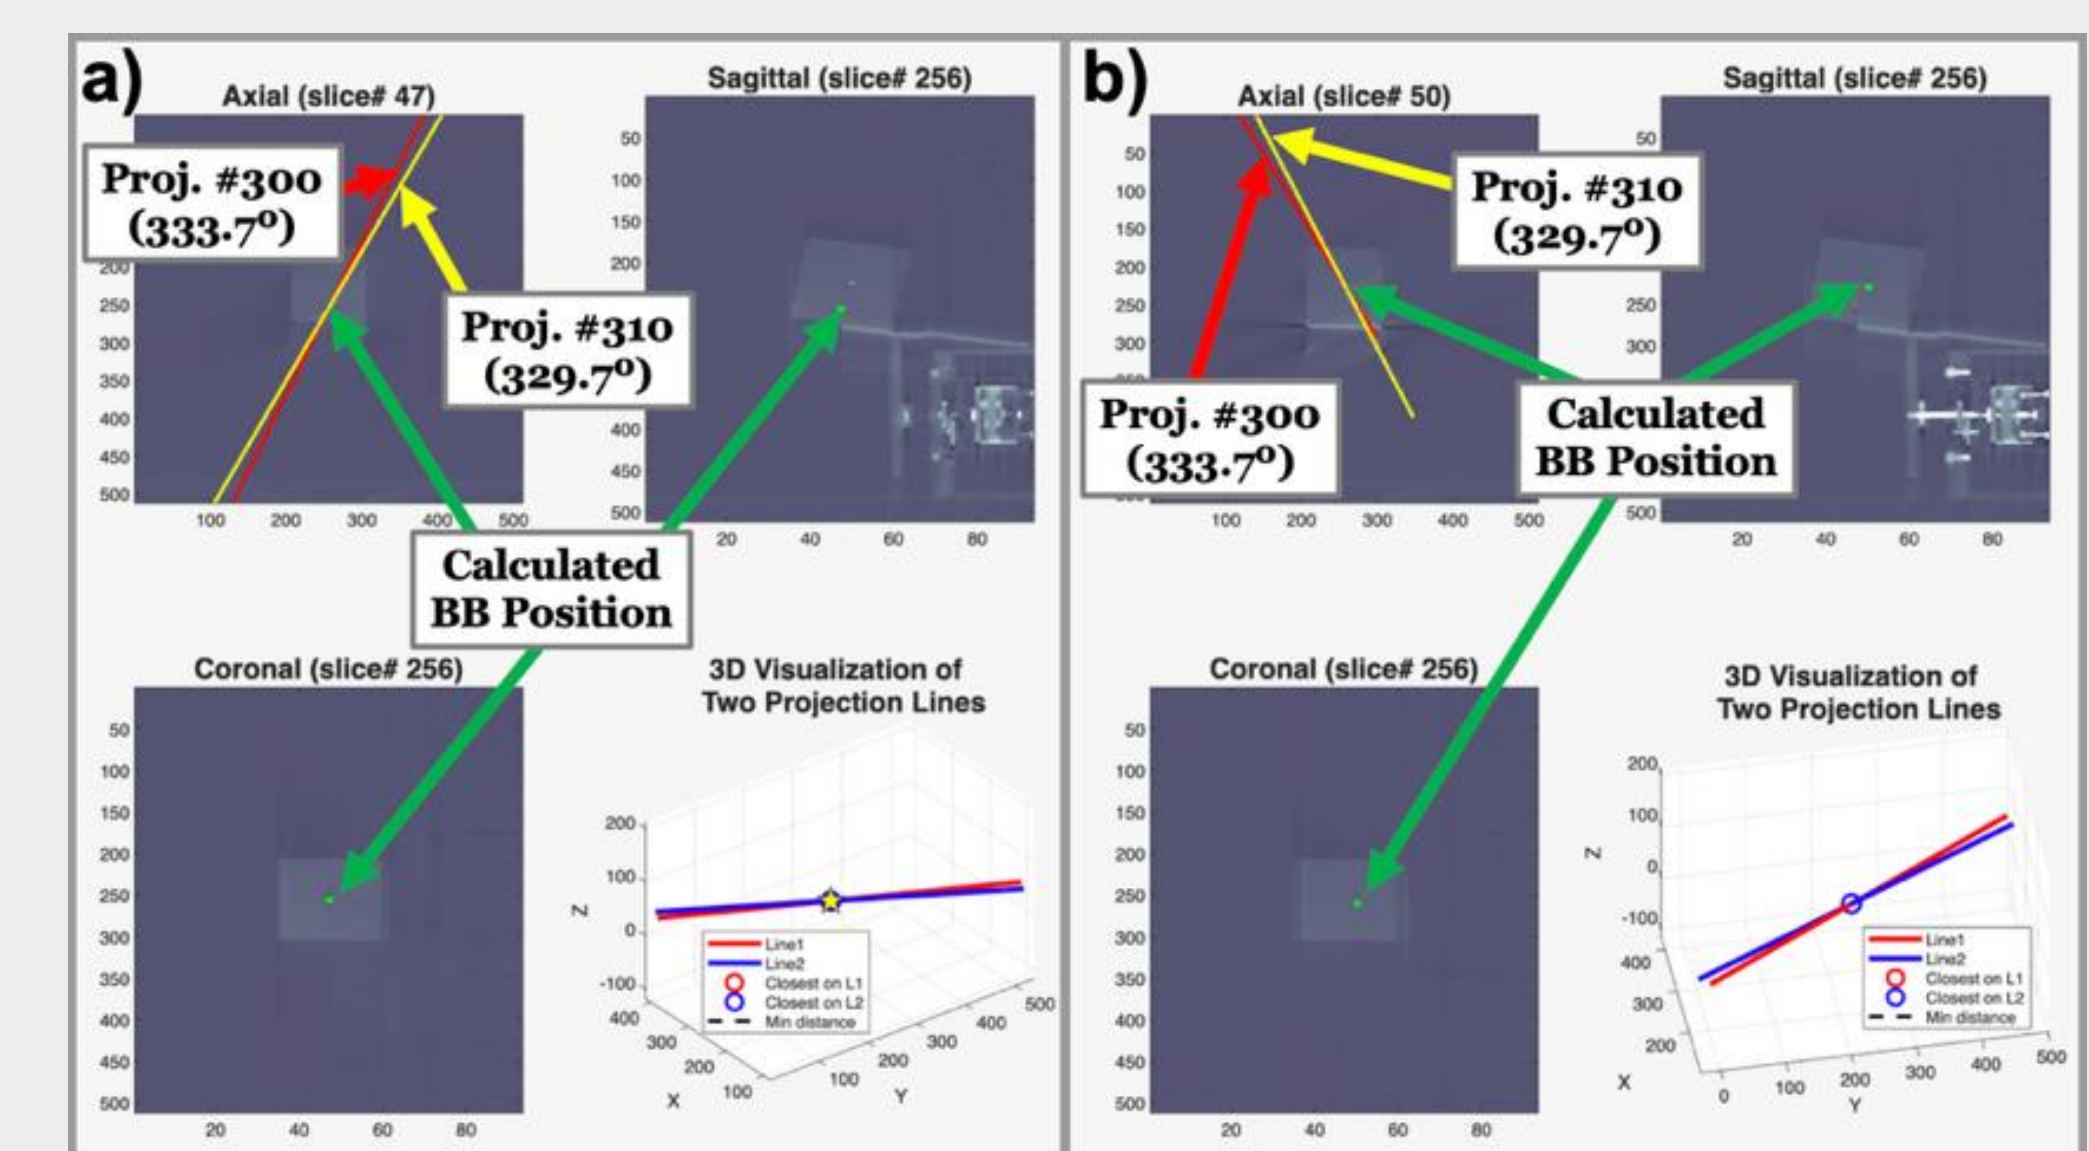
Calculated fiducial marker position (green dot) displayed on the CBCT image with two adjacent projections represented by back-projected lines (red and yellow).
